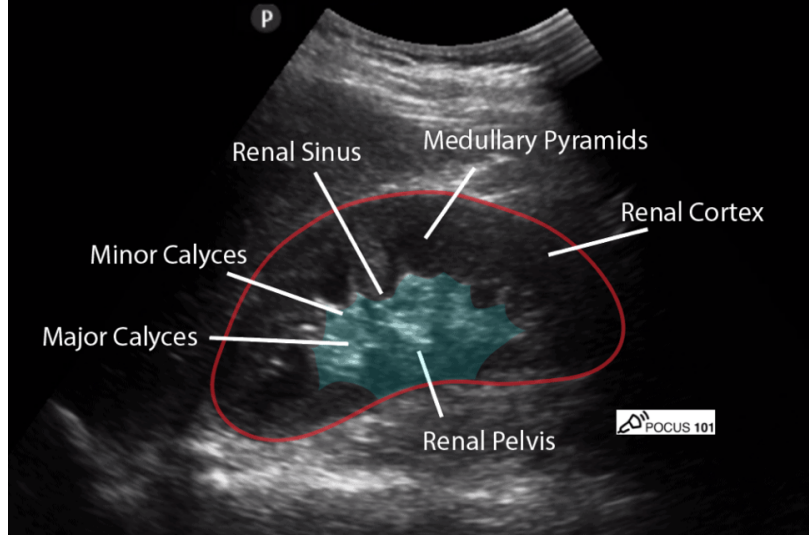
Longitudinal ultrasound image of a healthy kidney with red border outlining the organ. Internal structures display distinct echogenic properties, allowing clear differentiation of anatomical regions, such as the renal cortex, medulla, and pelvis(image reproduced from [62]).
